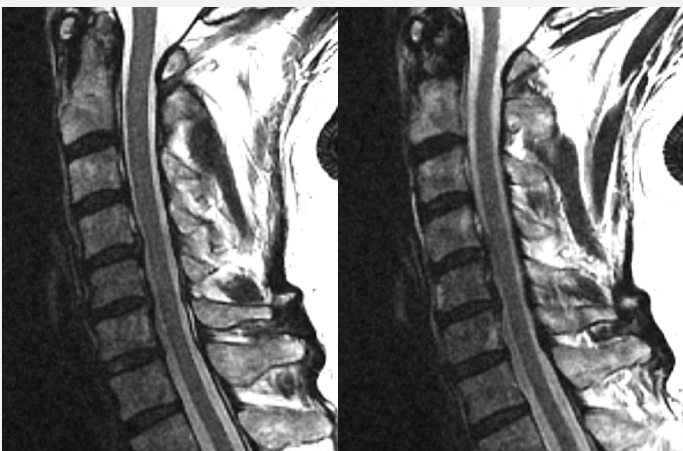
Pre-operative MRI | Mild degenerative disc disease from C4-6, and disc herniations at C4-5 and C5-6
